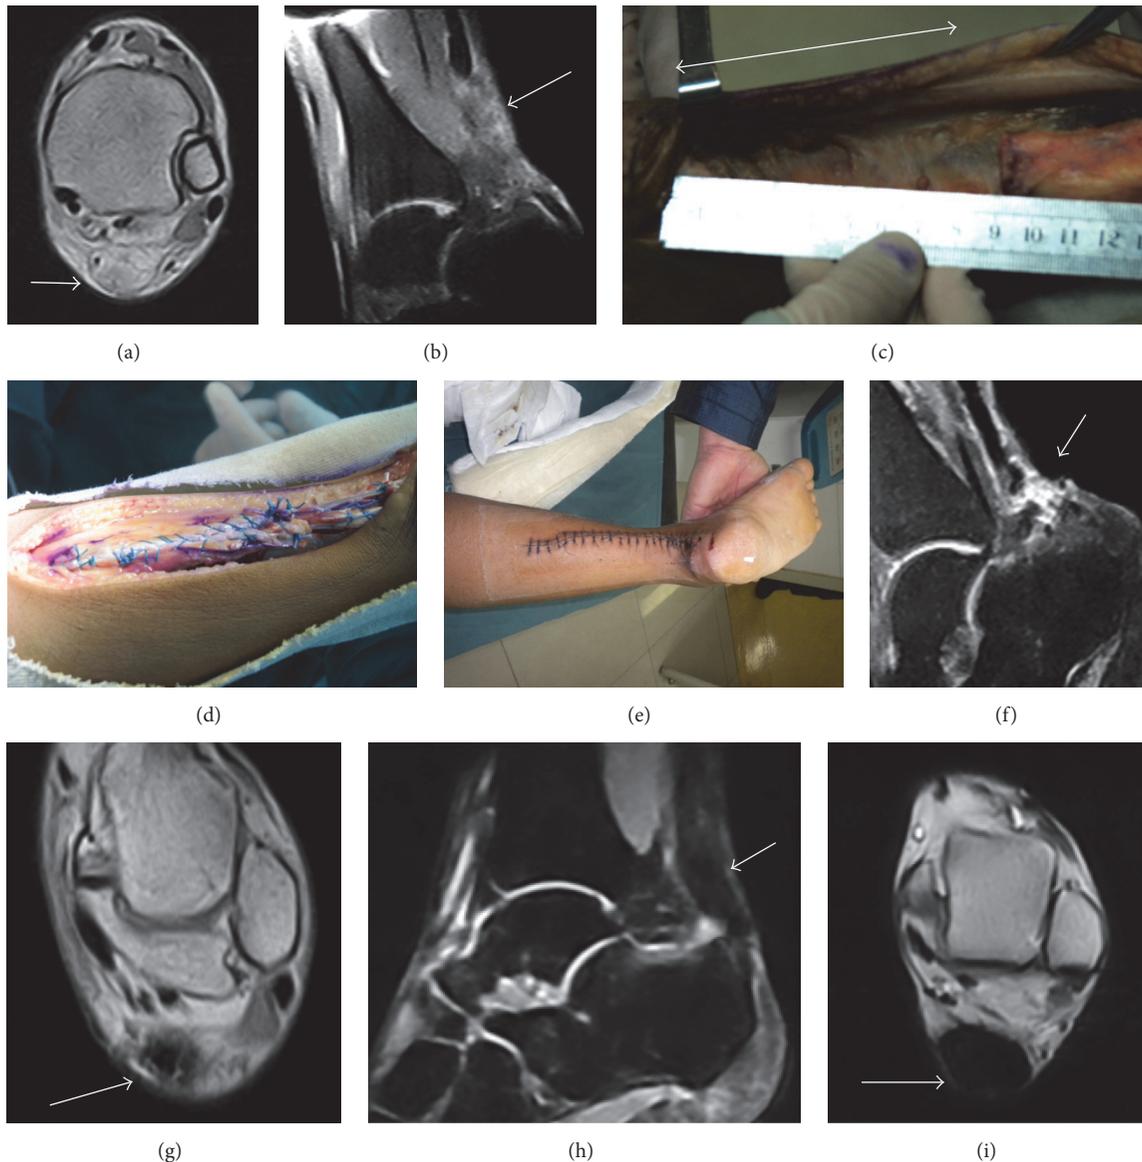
A 23-year-old male. The interval from rupture to surgery was 7 weeks. Preoperative MRI showed chronic Achilles tendon rupture (arrow) (a, b). Length of gap (double-headed arrow) was 9 cm after scar tissue debridement (c). V-Y advancement performed (d). Wound healed (e). MRI showing inflammation (arrow) at 6 weeks of follow-up (f, g). MRI showing fusiform-shaped tendon thickening and homogeneous low-signal at 1 year postoperatively (arrow) (h, i).
